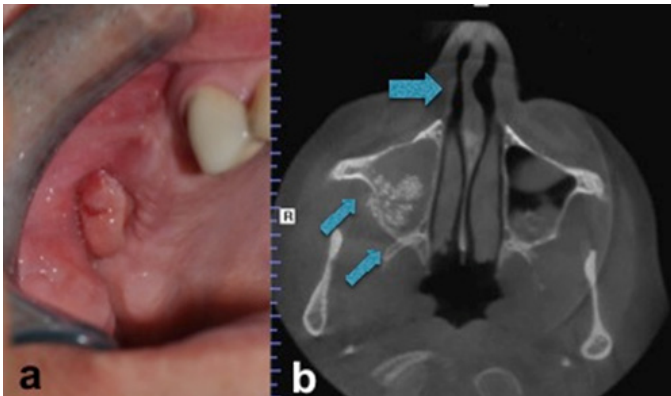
(a-b.) Intraoral appearance of the antral polyp (a). Axial view of the CBCT depicting right maxillary sinusitis (double arrow) and nasal septum deviation (arrow) (b).
